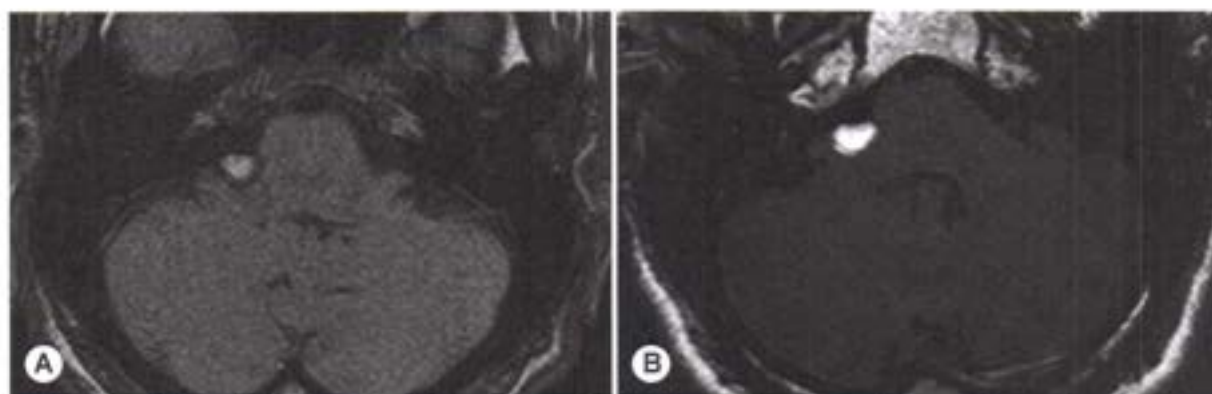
A) Axial T1-weighted MRI shows bilateral hyperintense cerebellopontine angle lesions. B) Axial T2-weighted 3-dimensional FIESTA (fast imaging employing steady-state acquisition) shows symmetric cerebellopontine angle lesions with areas of lower intensity consistent with encased vascular and nervous structures. C) Coronal IDEAL (iterative decomposition of water and fat with echo asymmetry and least squares estimation) imaging with water suppression emphasizes hyperintense signal of cerebellopontine angle lesions, reflecting their high fat tissue content. D) Coronal IDEAL fat-saturated T2-weighted imaging shows signal loss.
